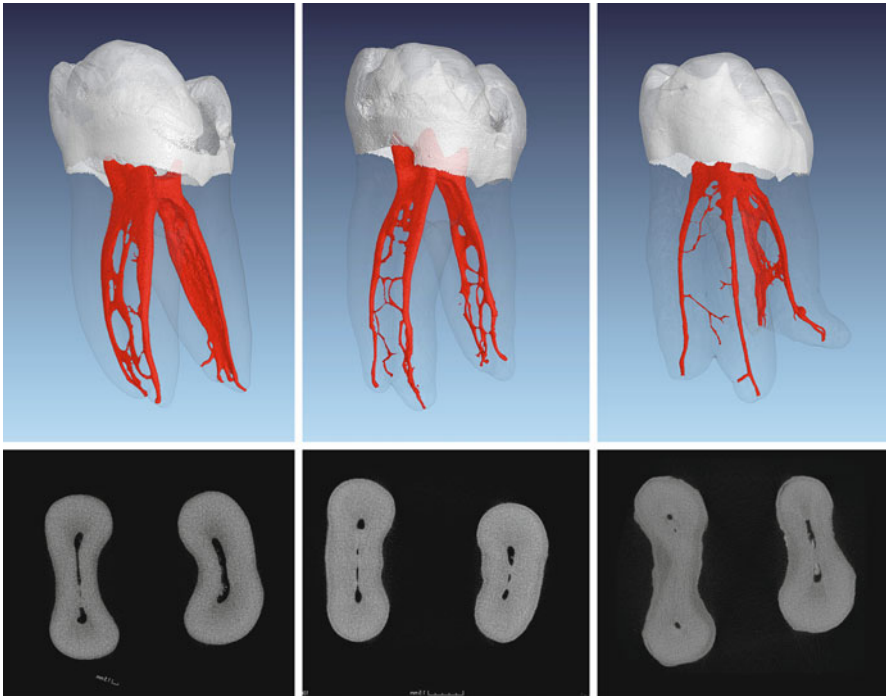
Micro-computed tomography images of extracted teeth from patients of different ages. Three-dimensional reconstructions and corresponding cross sections from the middle third of the roots are shown. Images from *left to right*: extracted tooth of a young-aged, middle-aged, and older patient, respectively. Note the width of the main canals and the number and size of various ramifications and communications
